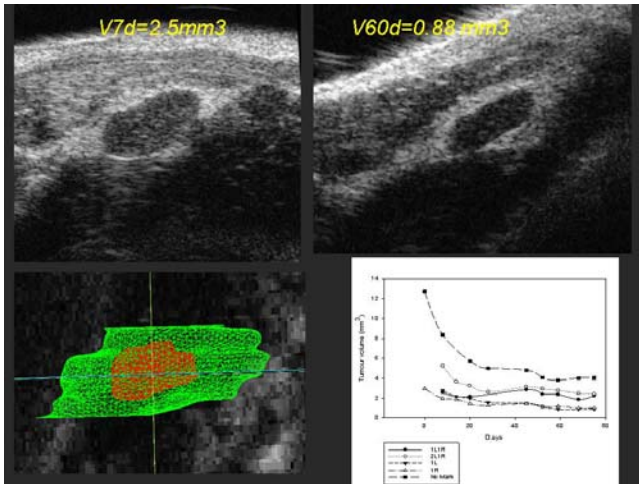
Ultrasound measurement of a xenografted PNF tumour fragment at 7 (left) and 60 (upper right) days after implantation. Lower left: red represents the core tumour implant while green may correspond to the inflammatory areas around the implant. Lower right: tumour volume measured weekly. The calculation was carried out using five different definitions of the boundary.
